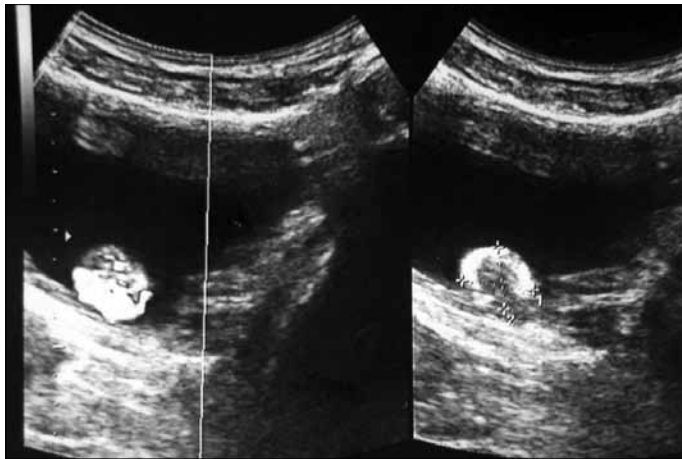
Ultrasonography revealing a 4 cm size heterogeneous mass in the bladder dome.
